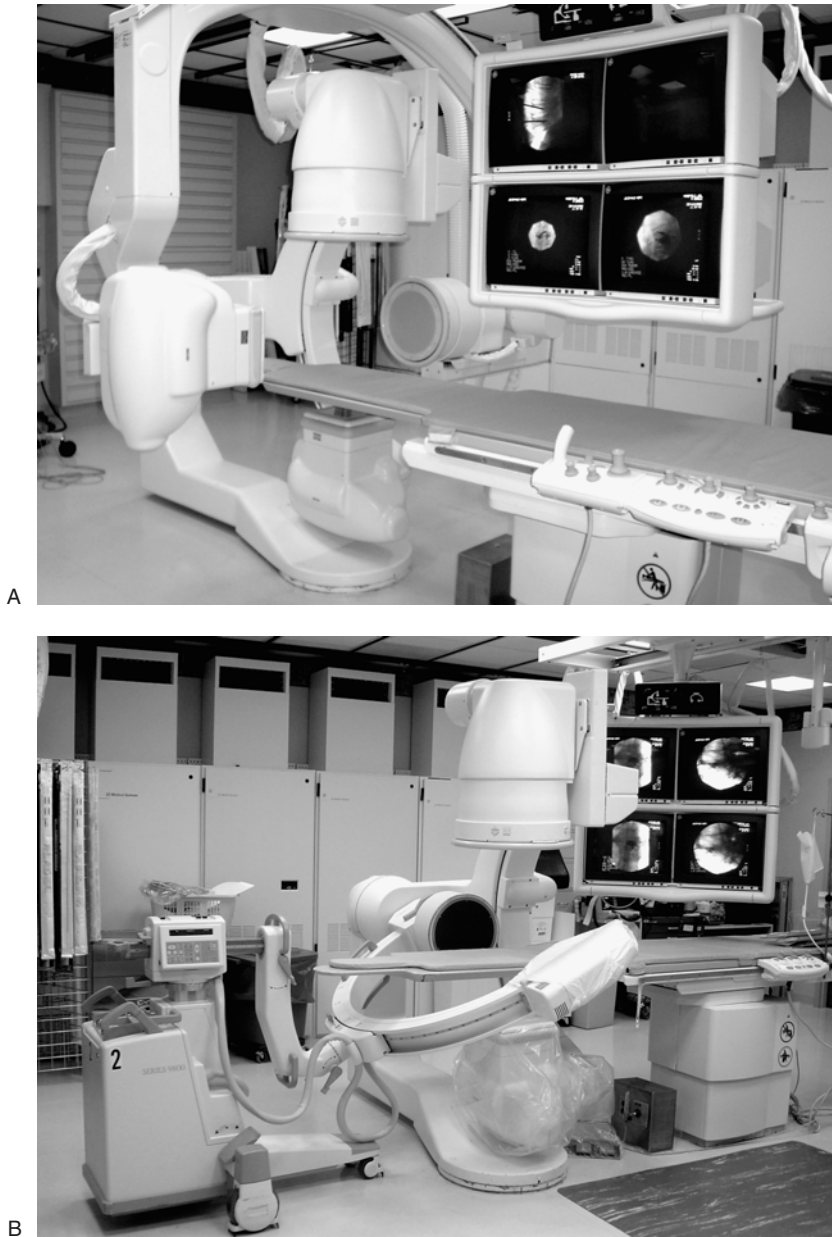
(A) Typical biplane configuration with independent imaging planes capable of producing images in two projections without complex equipment movements. (B) This shows a temporary biplane arrangement with a mobile C arm moved into position along with a fixed single-plane fluoroscopic system. Although not necessary routinely, this type of configuration may be advantageous when starting PV or KP to make the imaging acquisitions faster. (C) Combined CT and mobile fluoroscopy setup. In this arrangement, fluoroscopy may be constrained to lateral images only based on the size and configuration of the CT table. (A, from J.M. Mathis [ed], *Image-Guided Spine Interventions*. New York: Springer, 2004, with permission.)
